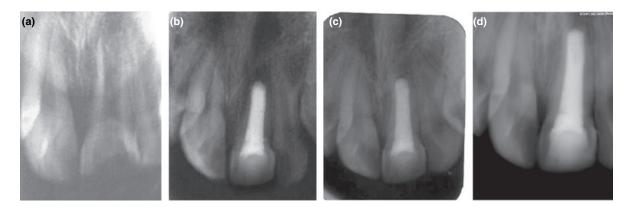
(a) A preoperative radiograph of maxillary central incisors with open apices. (b) Follow-up after 6 months (c) Follow-up after 1-year (d) Follow-up after 2 years.
